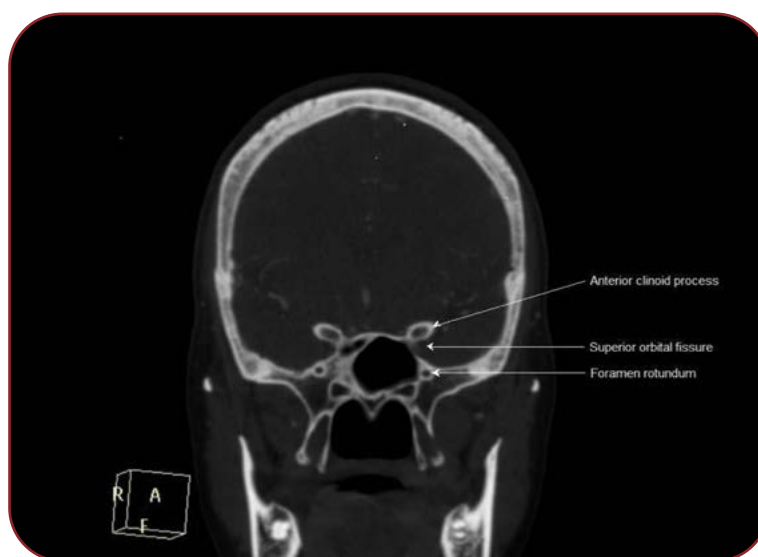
Foramen rotundum in computed tomography scan
